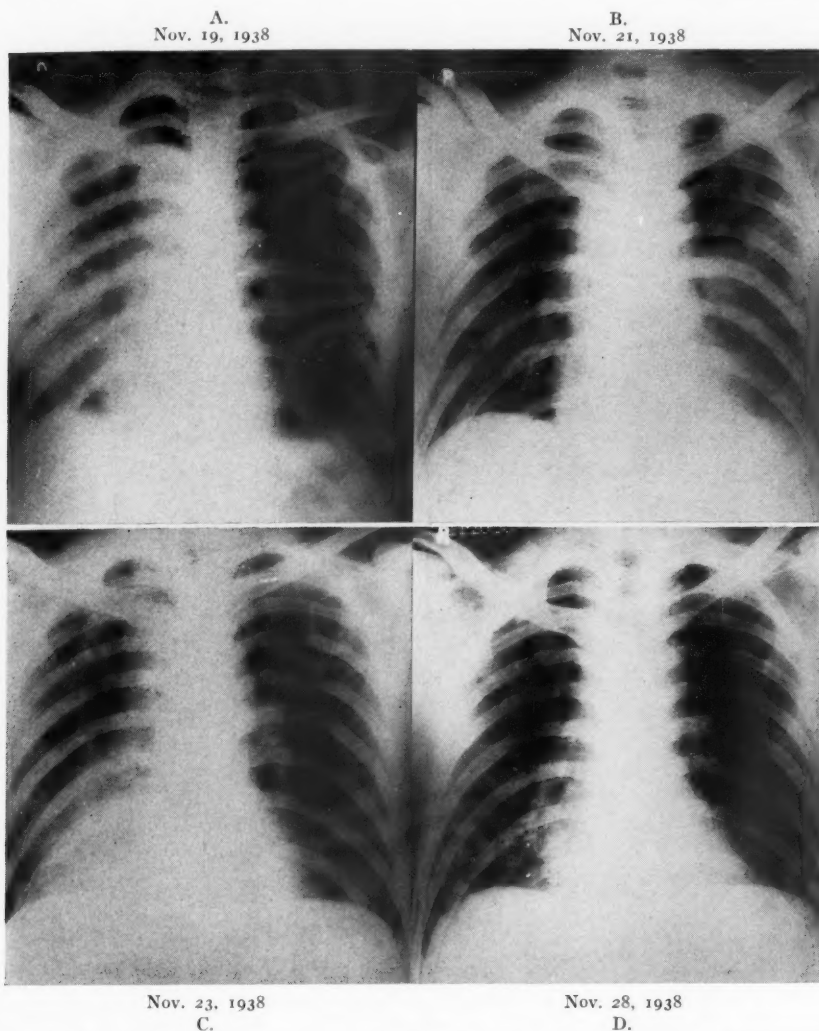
M. M., No. 372675: (A) Roentgenogram, Nov. 19, 1938, on first postoperative day following total gastrectomy shows partial atelectasis of right lung. Tracheobronchial suction on three occasions during a period of five hours. Improvement of voluntary cough, so patient treated by alternate lateral positions, one hour on left side and one-half hour on right, and by encouragement of frequent cough. (B) Roentgenogram, Nov. 21, 1938, two days later. Right lung almost clear. Pneumonitis has developed on left. Cough productive and effectual. Subsequent treatment by change of position at hourly and half-hourly intervals with patient kept one hour on right side and one-half hour on left. (C) Roentgenogram, Nov. 23, 1938, two days later. Return of atelectasis of right lower lobe. Left lung now clear. Position now changed more frequently than before to prevent stasis of secretions in more dependent lung. (D) Roentgenogram, Nov. 28, 1938, five days later. Clinical improvement with only slight residual pneumonia at right base.
